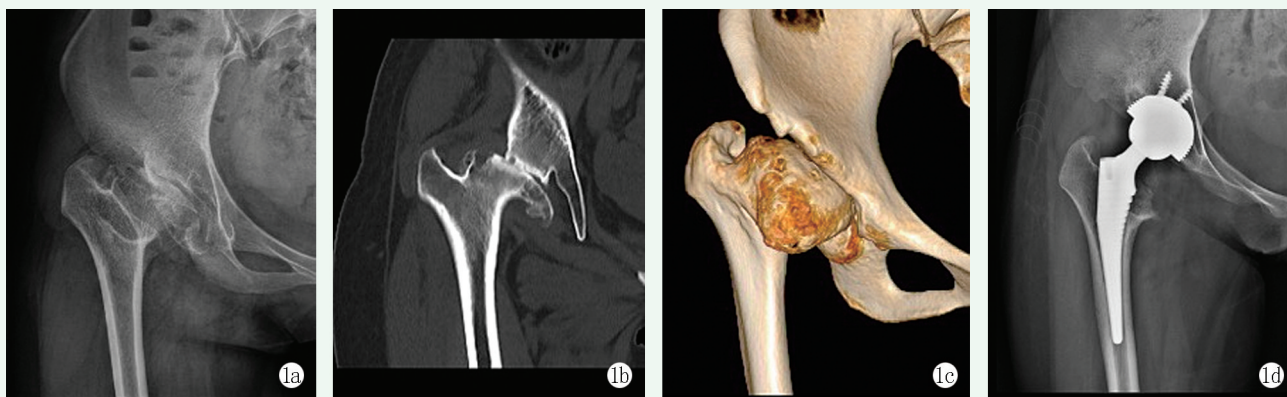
患者女性, 33 岁, 因右侧扁平髋 (Perthes 病) 行右侧人工全髋关节置换术。1a: X 线片示右侧髋臼浅, 股骨头变扁, 股骨颈遮挡显示欠清, 右侧沈通氏线欠连续; 1b, 1c: CT 及三维重建示右侧髋臼窝浅平, 右侧股骨头变扁、不规则并向外上方移位, 右侧髋关节间隙变窄; 1d: 术后 2 个月 X 线片示假体位置良好。
